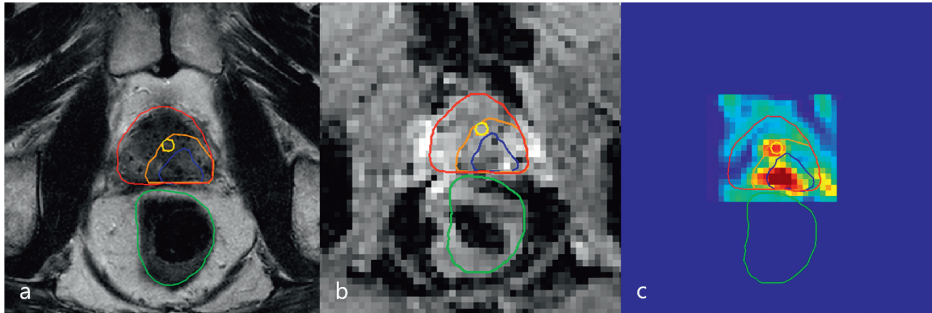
Diagnostic 3T mp-MRI revealing second recurrence lesion
